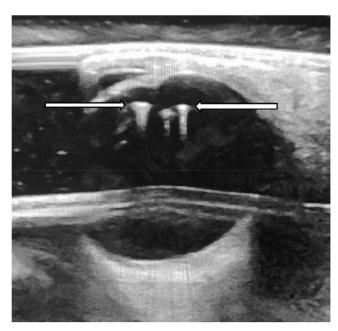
Ultrasonography of the left eye showing high reflective echoes of the three intraocular foreign bodies. The largest one on the left is in the lens and the two smaller echoes on the right are the intravitreal foreign bodies lodged behind the lens in the vitreous.
